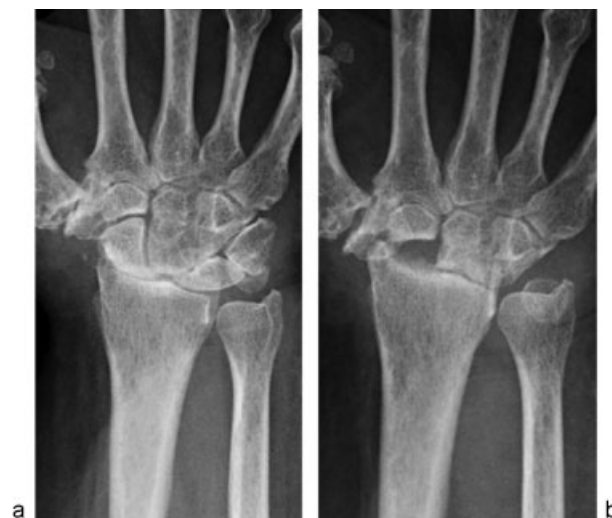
(a) PA preoperative X-ray image of a patient with SLAC wrist, different from the patient in Fig. 5a, b. (b) PA X-ray image 11.0 months postoperative for the patient in Fig. 6a. This patient's degeneration was graded as severe.
